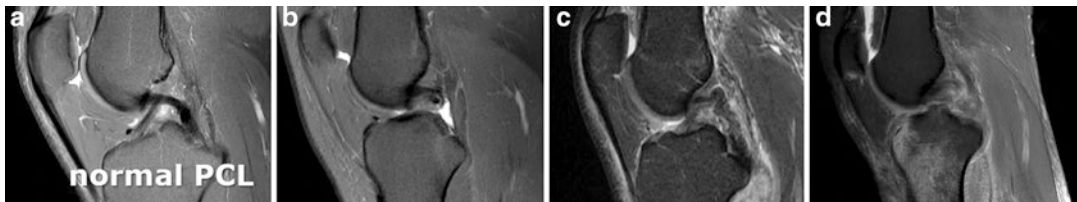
MRI sagittal views of knee posterior cruciate ligament injuries. (a) Normal PCL, (b) PCL distal tear, (c) PCL tortuosity and intra-substantial injury, and (d) PCL complete tear (sagittal PD Fat Sat MRI)
